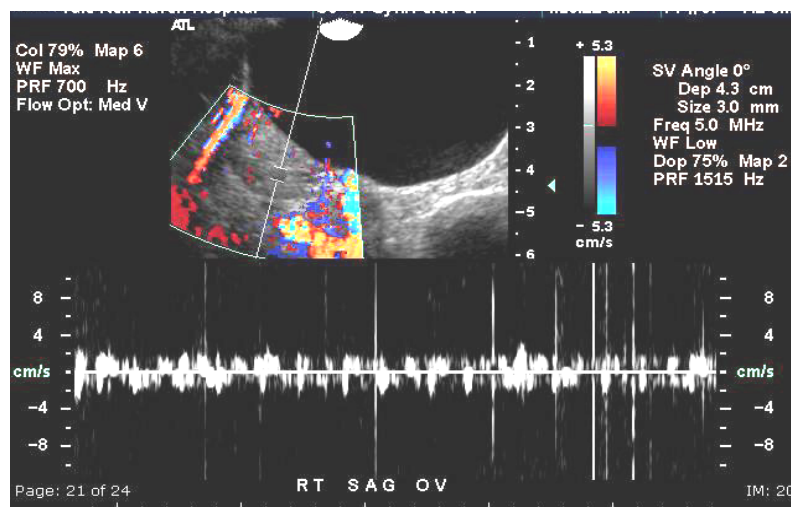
Ultrasound performed on one of the study patients demonstrating Doppler techniques.
